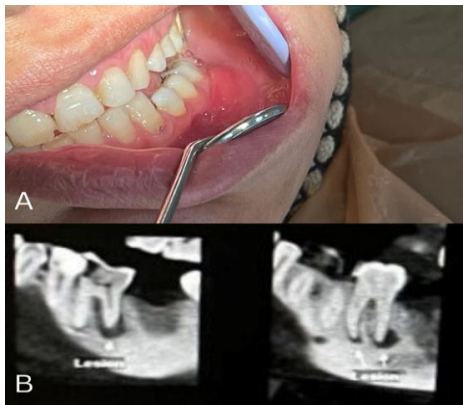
A) Clinical photograph showing swelling in the buccal mucosal fold adjacent to the left mandibular first molar. B) Sagittal CBCT section revealing a radicular lesion associated with the tooth
